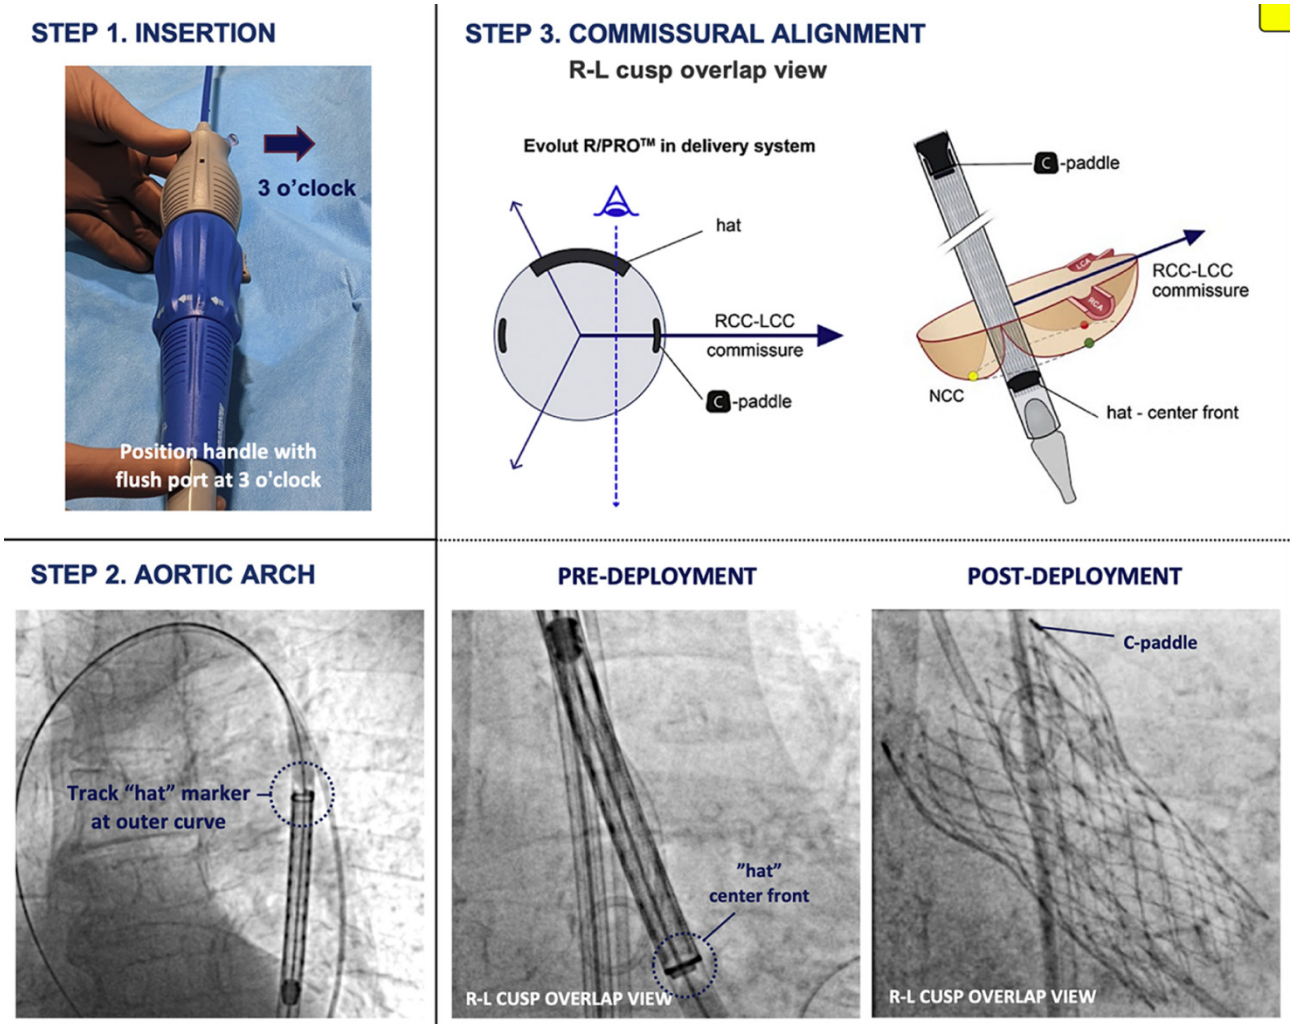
Strategies for commissural alignment based on fluoroscopic projection or prediction of TAVR system axial rotation. Orientation of the commissures in the Evolut crimped device based on angiographic projections (A). Orientation of the commissures in the ACURATE Neo2 crimped device based on angiographic projections (B). Patient-specific ACURATE Neo2 implantation with commissural alignment based on predicted rotation by computed tomography analysis (C)
